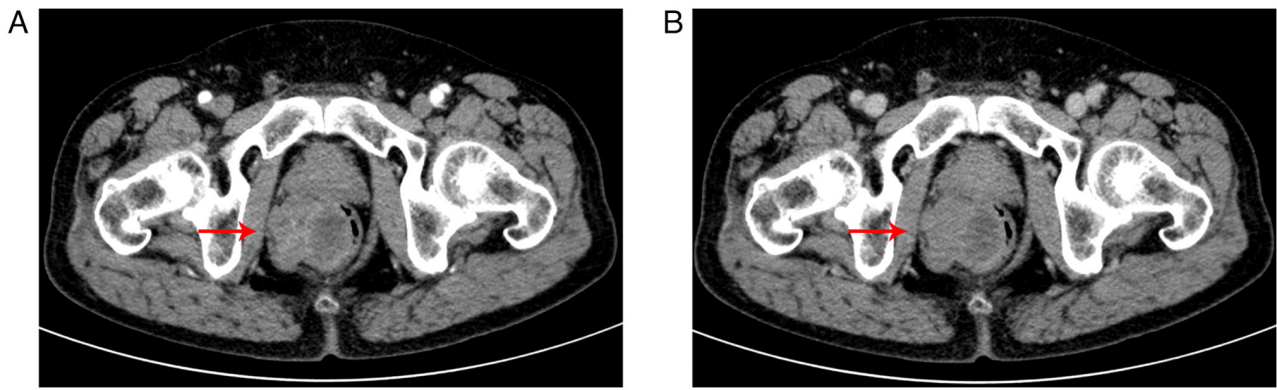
Contrast-enhanced CT. (A) Arterial phase of enhanced abdominal CT. (B) Venous phase of enhanced abdominal CT. The red arrow points at tumor. CT, computed tomography.
